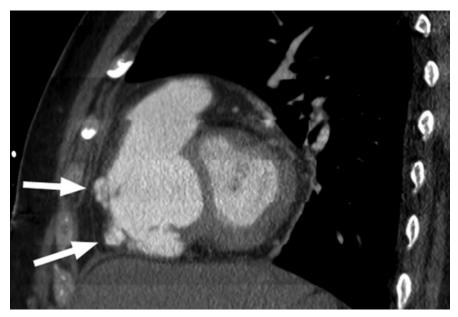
Short-axis reformatted computed tomography image revealing an irregular lobulated right ventricular contour in addition to two aneurysms arising from the right ventricular free wall (arrows).
